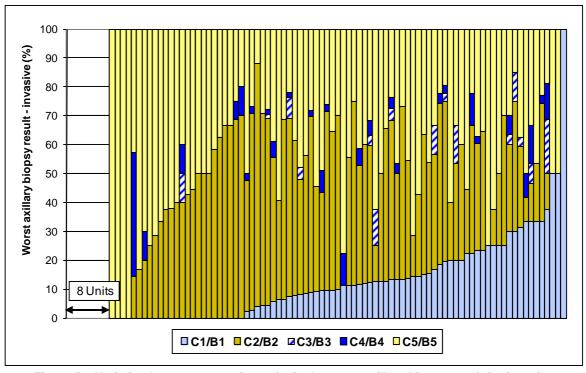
Variation between screening units in the worst axillary biopsy result for invasive cancers with an abnormal axillary ultrasound result – Data for Scotland are not available
